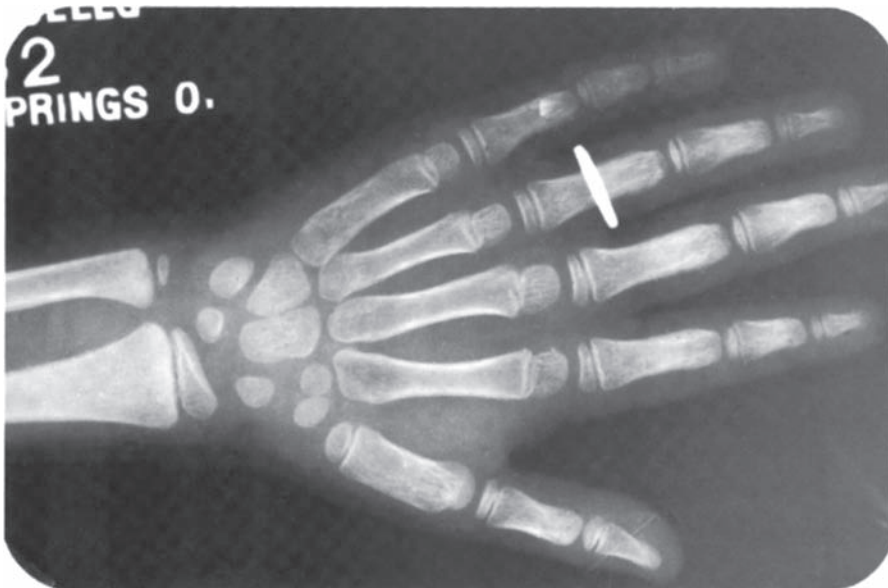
Hand-wrist X-ray of a 5-year-old.
